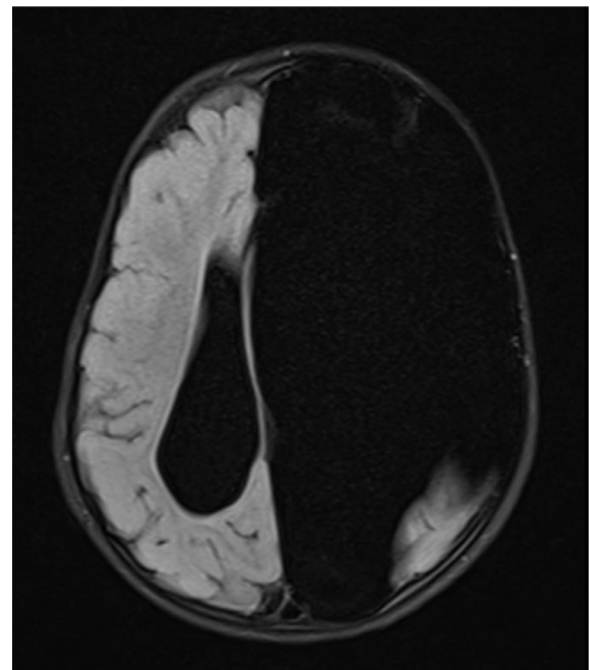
MRI brain demonstrates obstructive hydrocephalus with a mass effect in Axial T1-weighted image.
